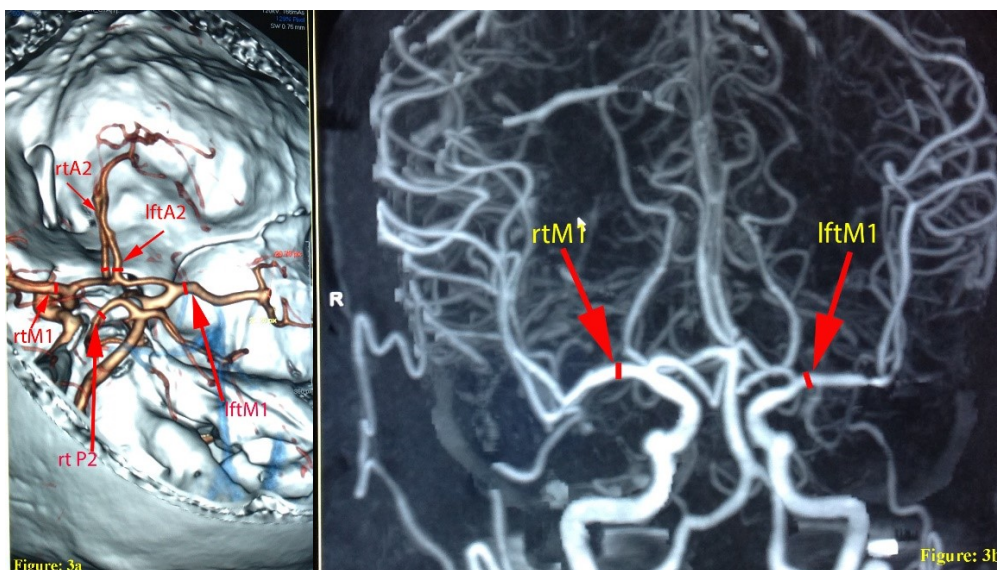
Figure showing the sites of arterial diameter measurement in reconstructive cerebral arterial Computed Tomography Angiography (CTA) and Magnetic Resonance Angiography (MRA), rt = right, lft = left, green lines showing the measurement sites of vessel diameters, A2 = the most proximal portion of second part of anterior cerebral artery and M1 = the most proximal portion of the first part of middle cerebral artery.
